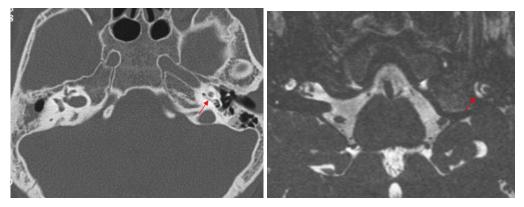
Preimplantation CT and MR. Arrows indicate an open cochlea on the right side.
